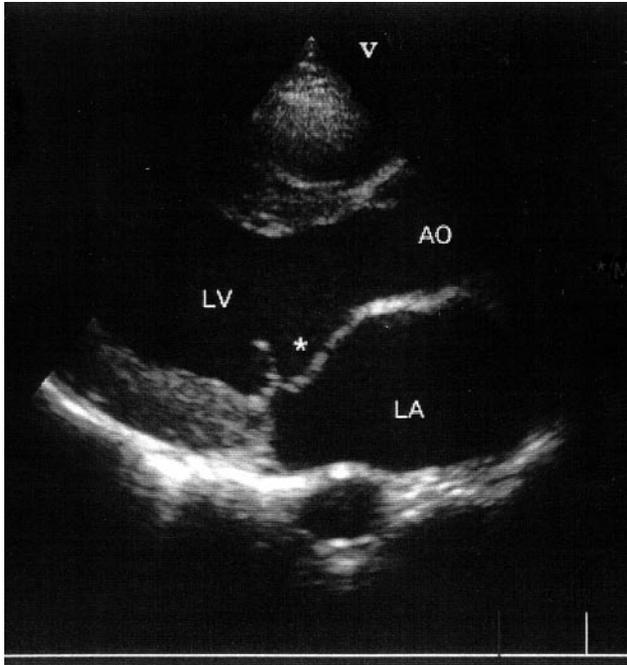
Echocardiographic parasternal long axis view showing prolapse of the anterior leaflet of the mitral valve (*).
